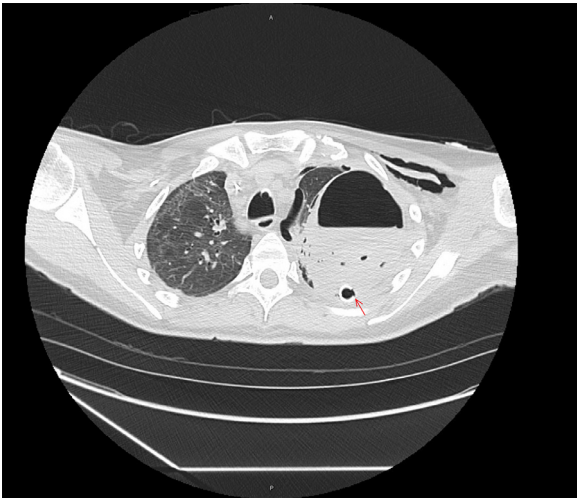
CT chest without contrast showing small left anterior pneumothorax, pneumomediastinum and large lateral collection of gas and blood within the left chest. A left chest tube is present with tip at the posterior left lung apex.
